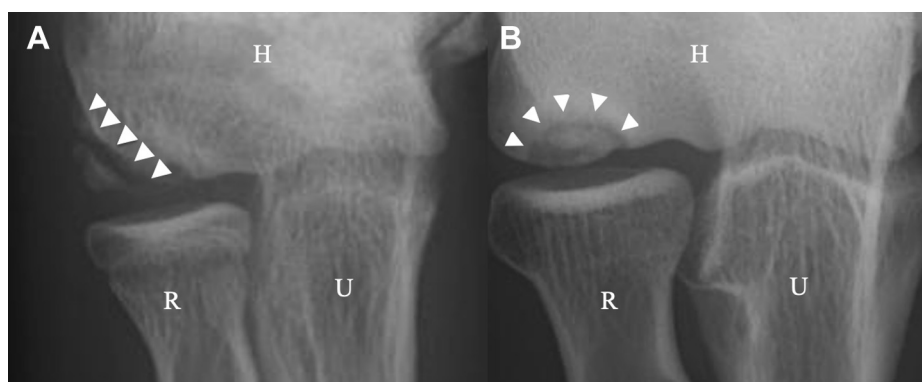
X-ray frontal images of the elbow. (A) Lateral type, (B) Central type. White arrowheads show lesion locations. H, Humerus; R, Radius; U, Ulna.
